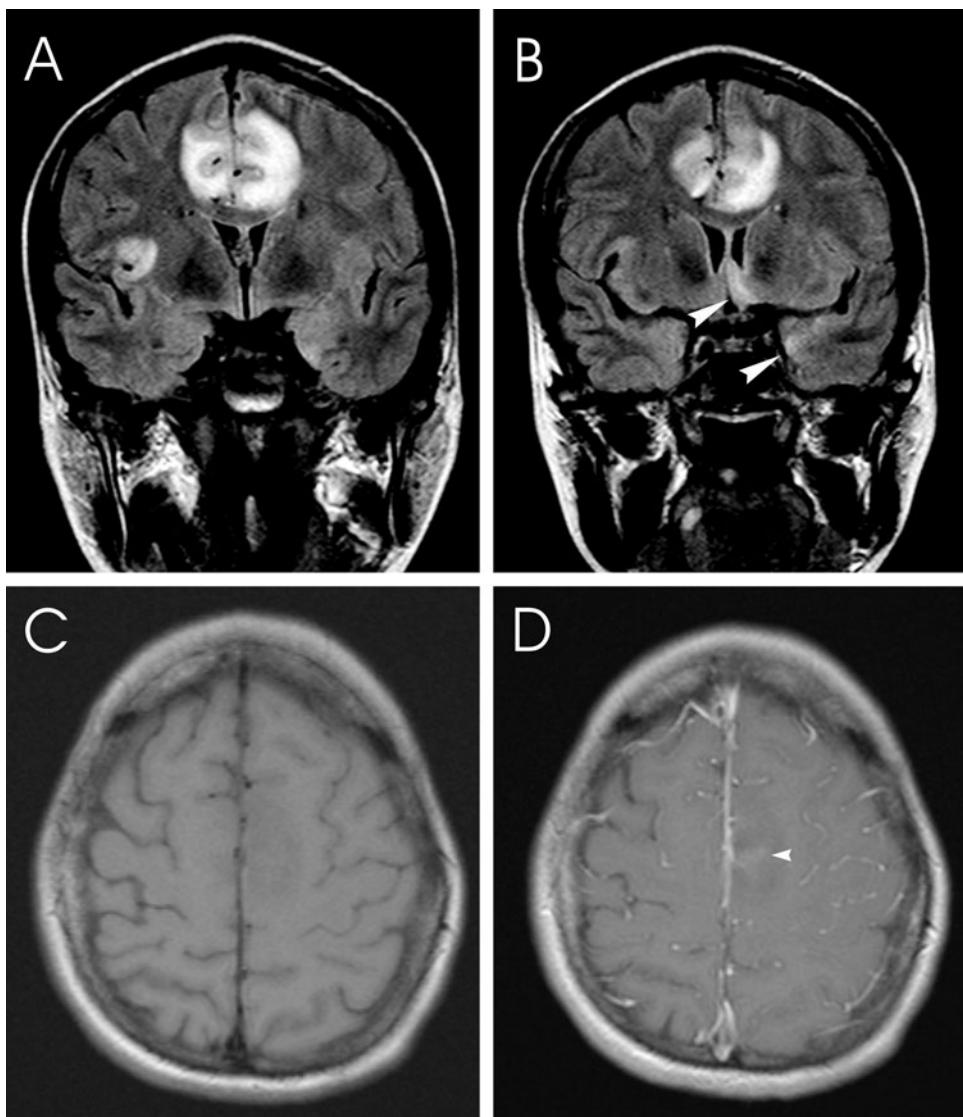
Follow-up MRI 3 days after the initial MRI, coronal FLAIR (A and B) with more right insular involvement (A) corresponding to the area of diffusion abnormality seen on the earlier diffusion image (Figure 1E) and greater involvement of the cingulate gyri (B) compared to the earlier scan with involvement of left mesial temporal lobe and subcallosal region (B, arrowheads), which is more typical for herpes simplex encephalitis. T1 axial pre- (C) and post- (D) gadolinium showing enhancement in the area of T2 abnormality in the left frontal lobe (arrowhead).
